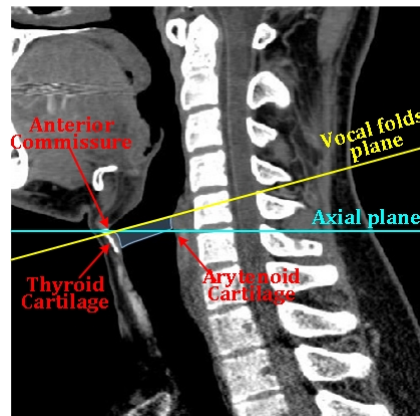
CT axial plane not aligned in the vocal folds plane
